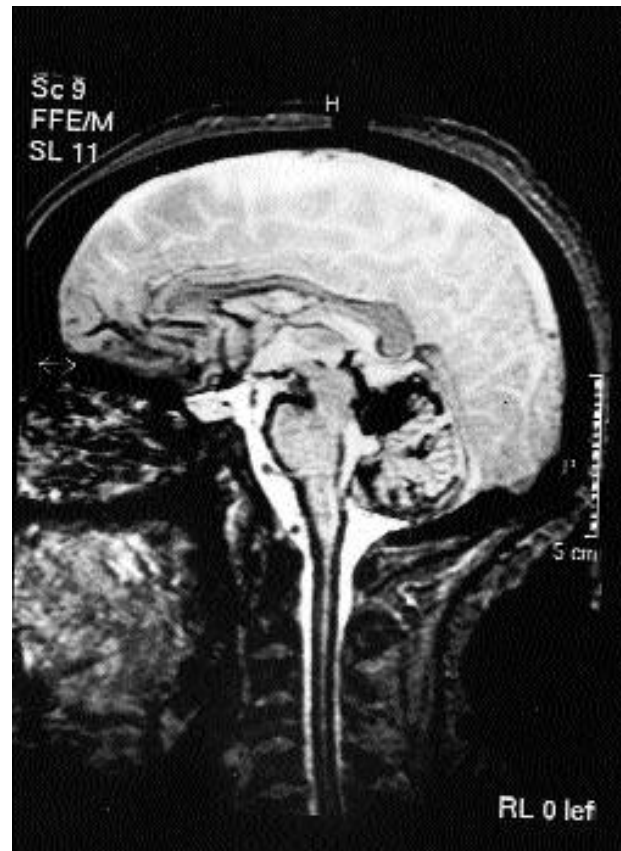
Sagittal T₂ fast spin echo magnetic resonance image showing hypointense rim of haemosiderin around the brainstem, cerebellum and spinal cord.
